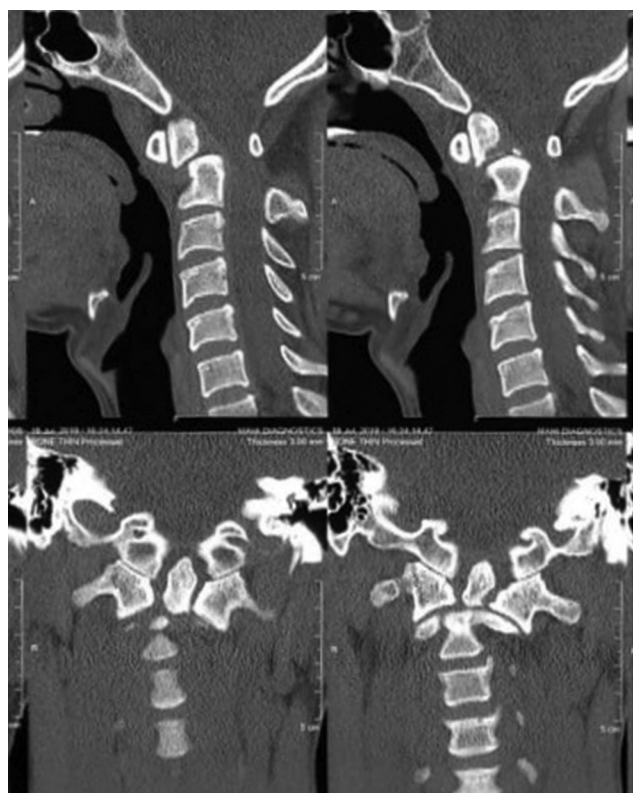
Preoperative sagittal and coronal view of type 2 odontoid fracture with atlantoaxial dislocation (AAD) on computed tomography (CT) scan.
